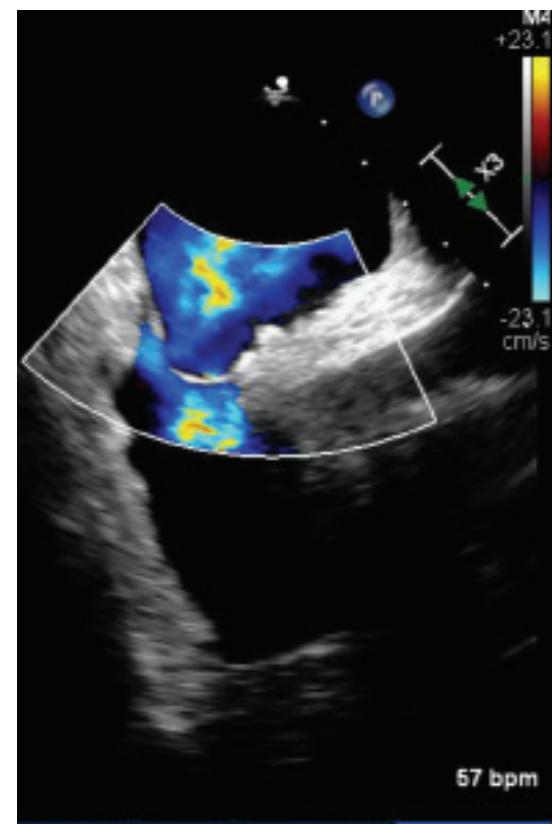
Color Doppler in bicaval view on TEE shows left-to-right shunt.
